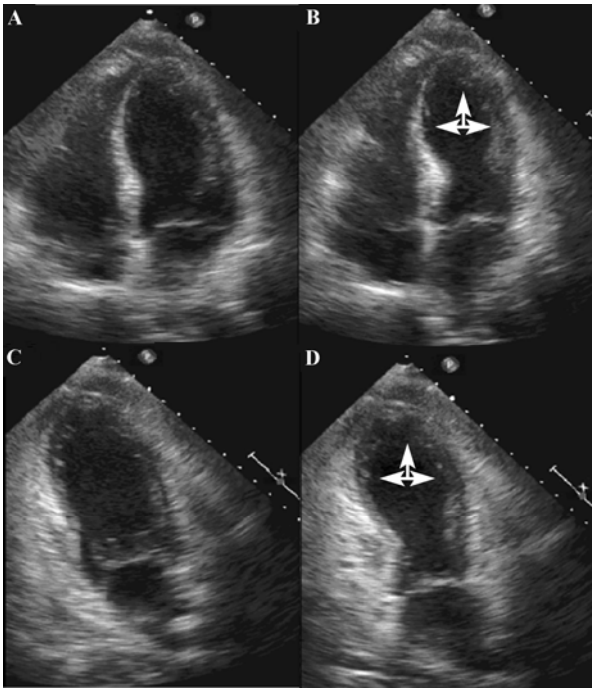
Case 1, echo still frames. (A): Apical 4 chamber view, diastole; (B): Apical 4 chamber view, systole; (C): Apical 2 chamber view, diastole; (D): Apical 2 chamber view, systole. Arrows indicate akinetic areas.
